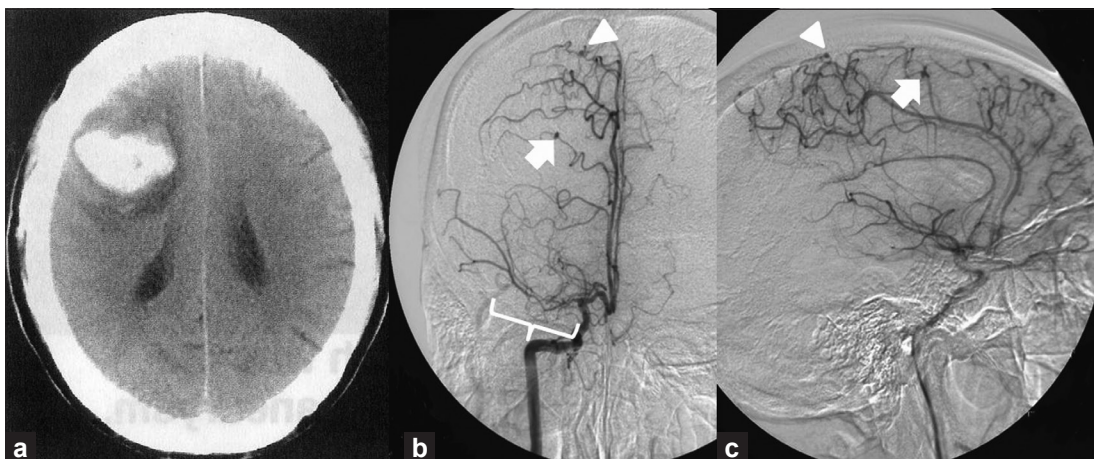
Case 1: neuroimaging findings on admission. (a) Axial computed tomograph (CT) showing an intracerebral hemorrhage in the right frontal lobe. (b, c) Digital subtraction angiograph (DSA) showing severe right middle cerebral artery stenosis (parenthesis) and two aneurysms in the posterior internal frontal artery and paracentral artery of the ACA (thick arrow and arrowhead, respectively) that functioned as collateral pathways
